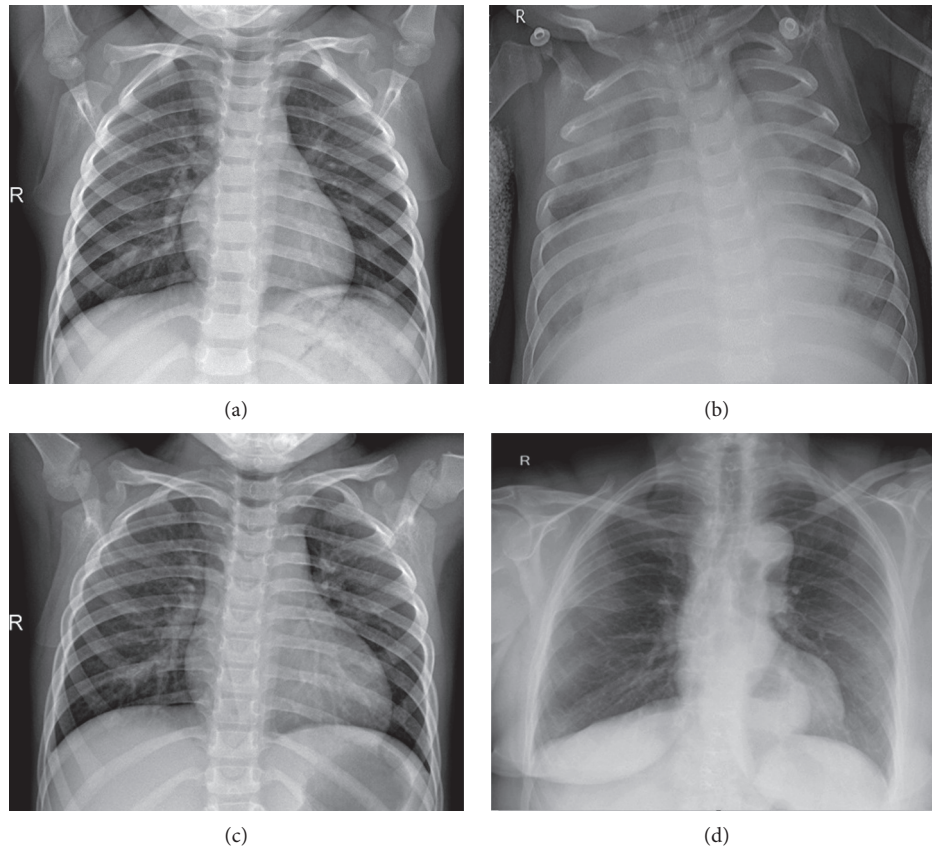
Chest X-ray images: (a) healthy, (b) bacterial pneumonia, (c) viral pneumonia (not COVID-19), and (d) COVID-19 infected.
